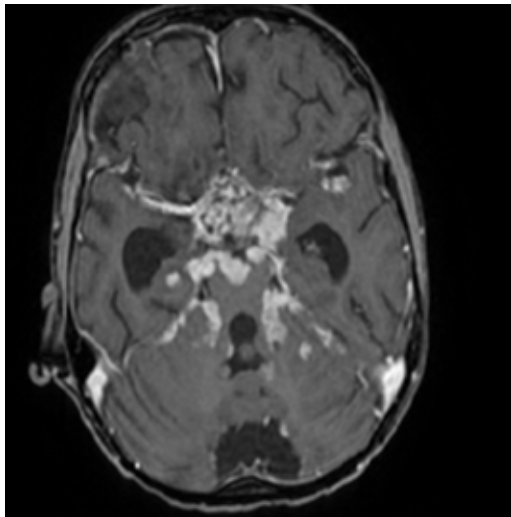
Axial Brain MRI - Multiple polylobulated masses, with intense contrast enhancement – suggestive for leptomeningeal dissemination
